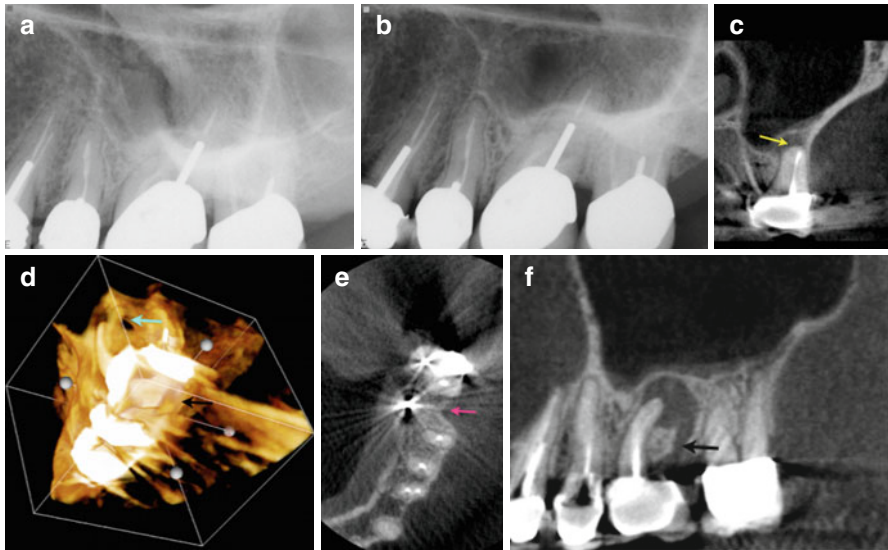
Patient was referred for consultation and treatment of a previously treated tooth #14. Patient presented with a sinus tract related to tooth #14. (a, b) Periapical radiographs of tooth #14, mesial and distal angles, respectively. (c) Coronal view of the mesiobuccal root showing a missed mesiobuccal canal (*yellow arrow*). (d) 3D reconstruction showing a crestal bone defect (*blue arrow*). (e) Axial view showing a previous distobuccal root amputation site (*purple arrow*) that was not obvious on the periapical radiographs. (f) Sagittal CBCT view showing the crestal defect communicating with the periapical lesion (*black arrow*) and elevating the floor of the maxillary sinus with no evidence of sinus perforation
